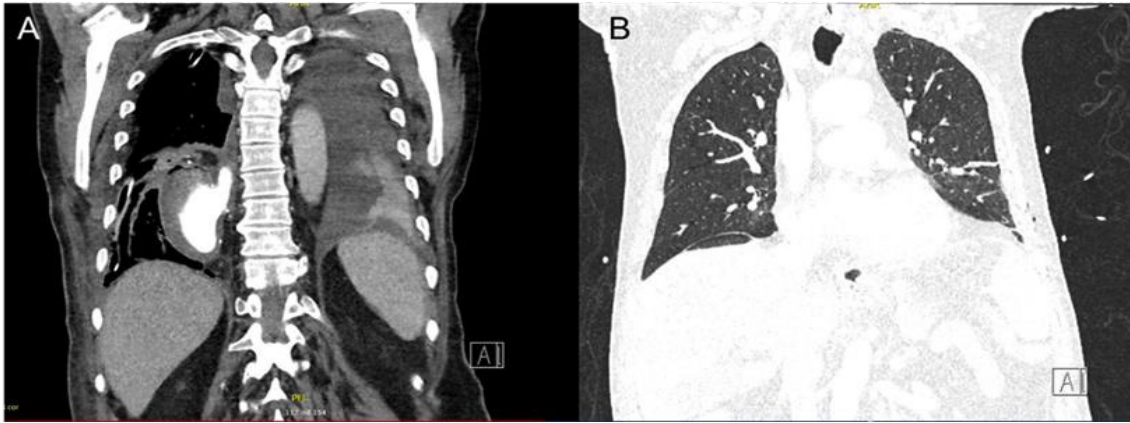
CT thorax with triple contrast on day five.
